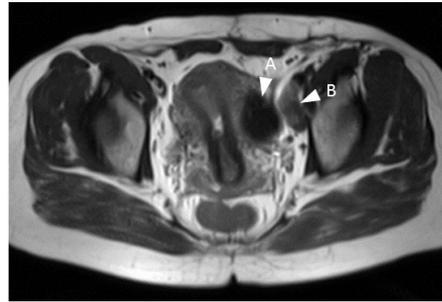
Pelvic MRI study (T2-weighted image) showed a low-intensity solid tumor of left ovary (arrow A) and significant enlargement of an obturator lymph node (arrow B).
